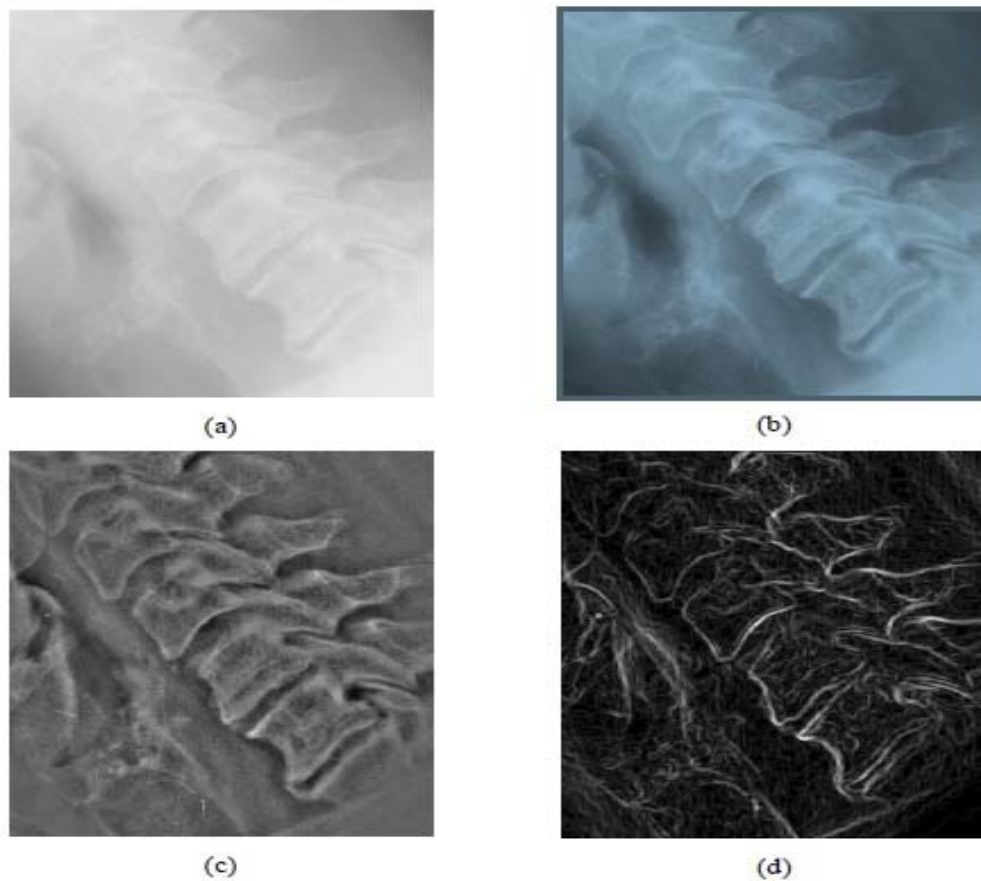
(a) A section of original X-ray image of cervical vertebra. (b) Enhanced image after adaptive histogram equalization, (c) Enhanced image after adaptive histogram equalization and unsharp masking, (d) Enhanced image after applying 3rd Derivative of Gaussian separable steerable filters ($\mu = 0.09, \sigma = 1.5$). (Cheng, 2006).
